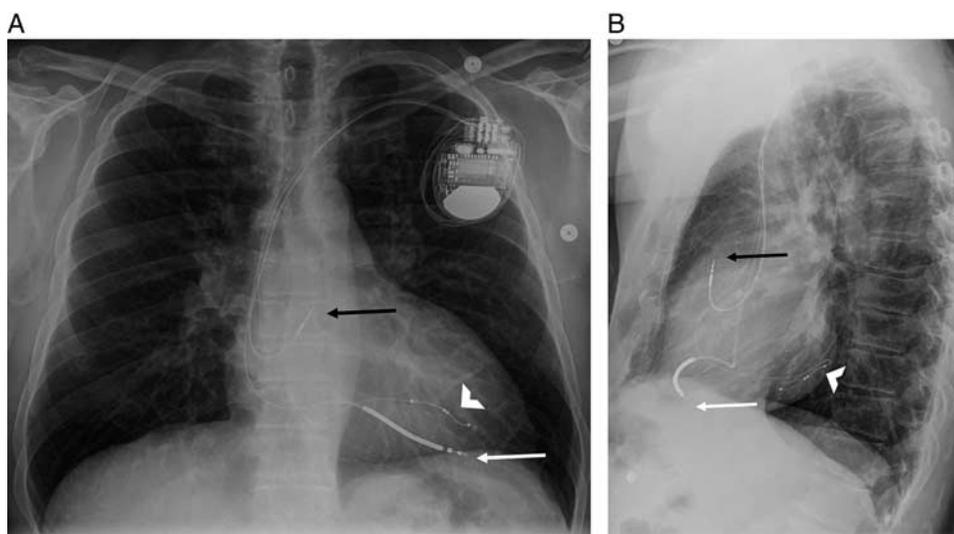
Permanent transvenous biventricular automatic ICD: frontal (A) and lateral (B) radiograph depicting biventricular automatic ICD/pacemaker with leads in the right atrial appendage (black arrow), RV (white arrow), and coronary sinus (white arrowhead). Note that the coronary sinus lead courses leftward on the frontal, but posterior on the lateral view.
